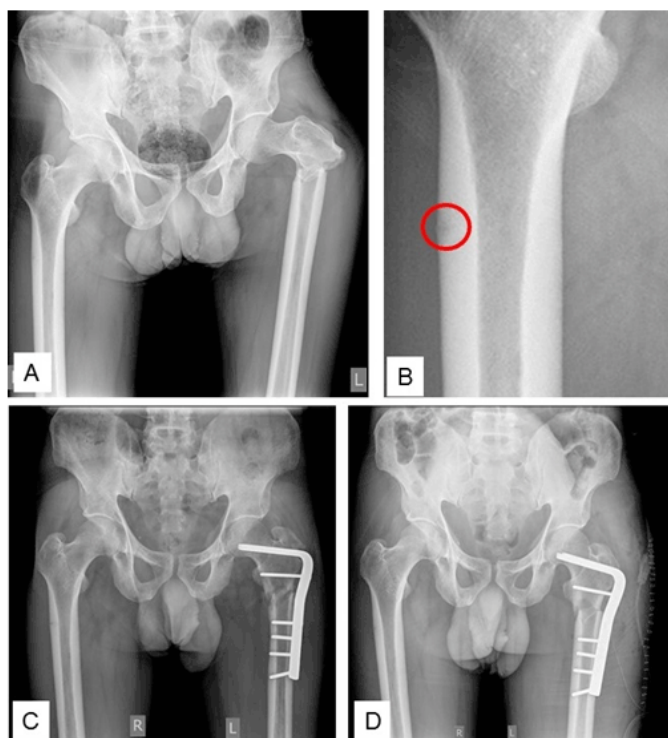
(A) Radiograph showing anteroposterior view of both proximal femurs at the time of presentation, (B) Magnified view of the lateral cortex of right femur showing cortical stress reaction (red circle), (C) Immediate postoperative radiograph, (D) Radiograph taken during ninth month follow-up showing no evidence of union.
